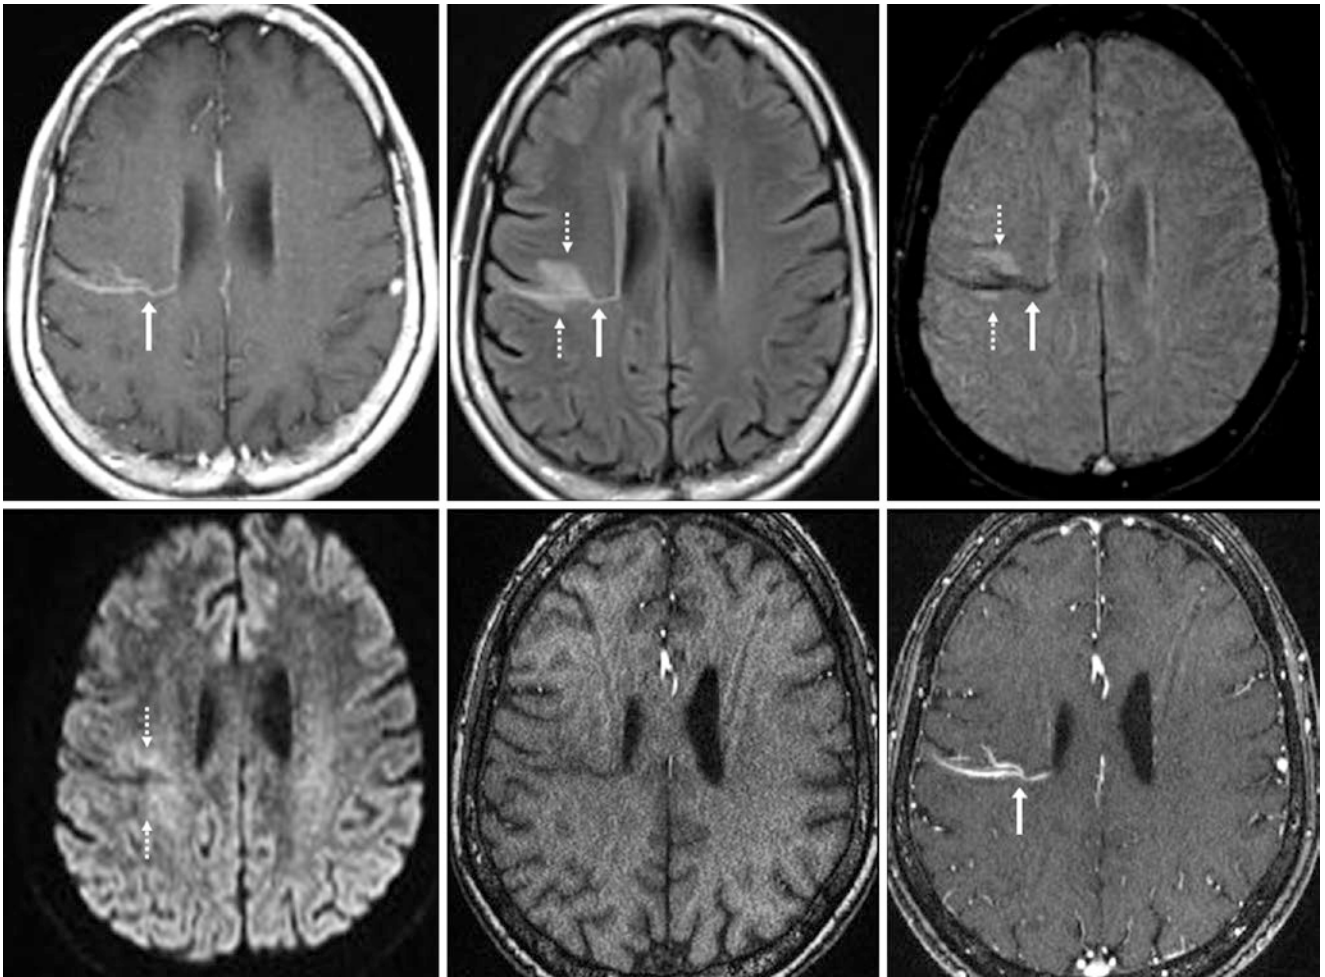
Comparison case of DVA with venous ischemia. A 65 year old had had a known DVA, with the draining vein (*arrows*) shown on a postcontrast SET1WI (*top left*) from a 1.5T MRI. Six months later, the patient presented with acute left facial numbness. There was edema surrounding the DVA (*dotted arrows*) on postcontrast FLAIR (*top middle*)
